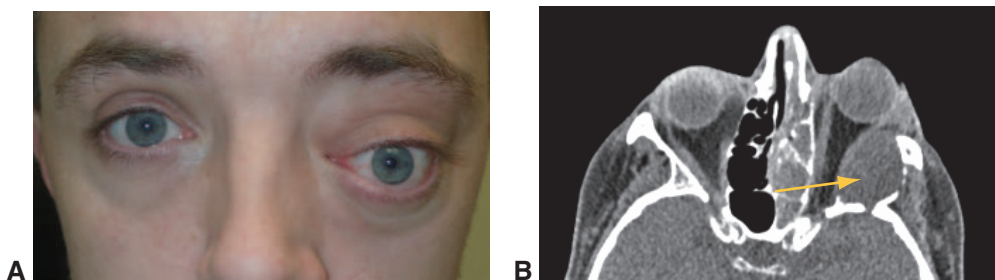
Metastatic prostate cancer. A, Left proptosis and orbital congestion in a patient with prostate carcinoma. B, CT scan shows a left posterior orbital mass (arrow) with an adjacent osteoblastic bony lesion confirmed by biopsy to be metastatic prostate cancer. (Courtesy of Steven M. Couch, MD.)
